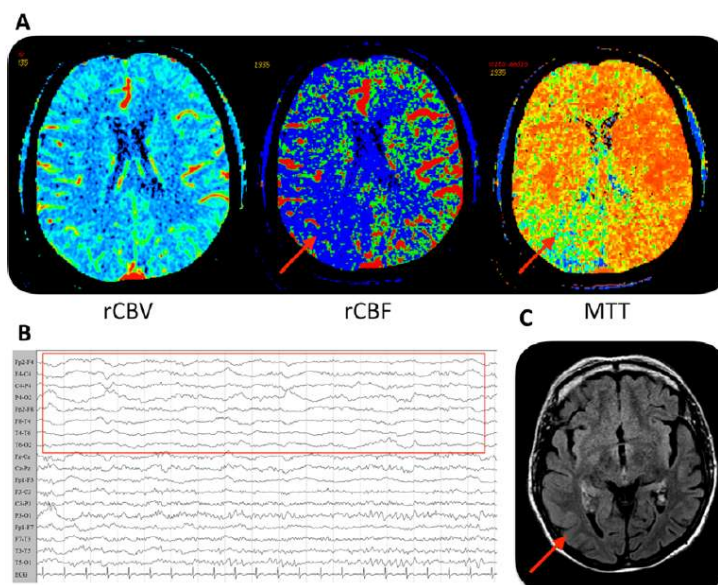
Postictal hypoperfusion. A 77-year-old woman presented to the emergency department for acute confusional state and left hemiparesis. A, Computer tomography perfusion shows, on the right hemisphere, normal rCBV, diffuse reduction of rCBF, and increased MTT in the parietal region. B, The EEG shows diffuse right hemisphere slowing. C, The FLAIR sequence on the MRI performed 24 h after the admission shows mild temporoparietal right cortical signal hyperintensity
